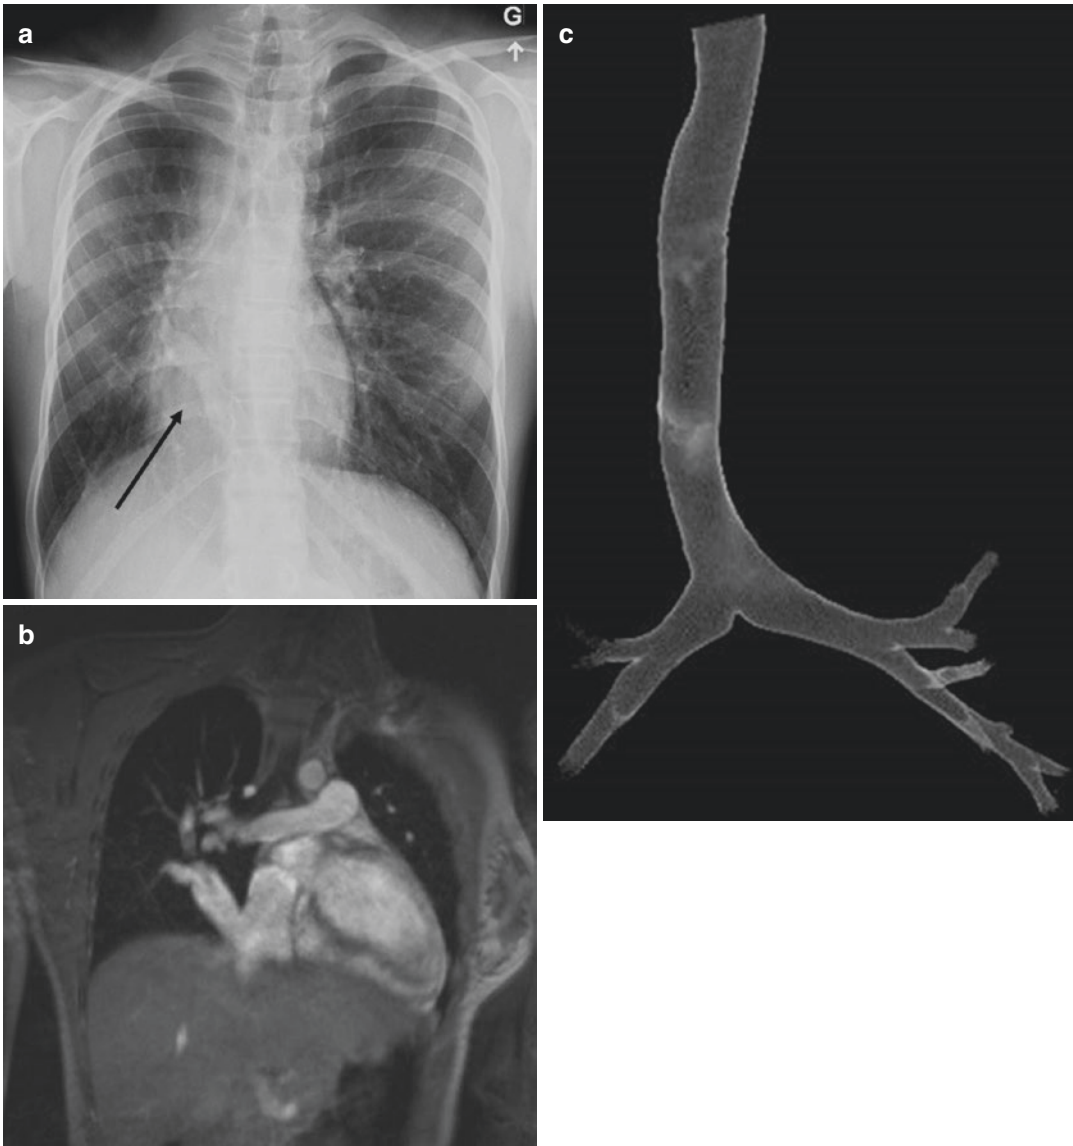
Scimitar syndrome. (a) Frontal chest radiograph shows hypoplasia of right lung, cardiac dextroposition, and a crescent-shaped abnormal vein (*black arrow*). (b) Coronal oblique view image obtained from cine FLASH
